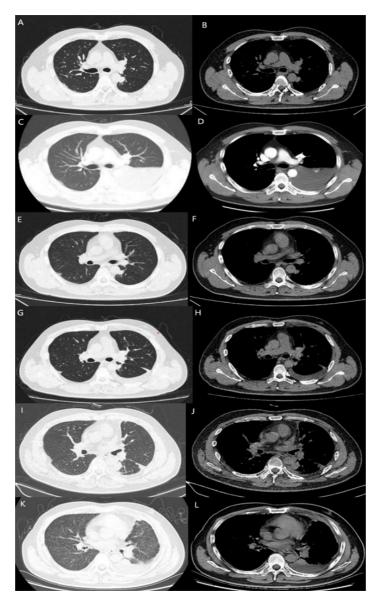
Chestcomputed tomography A and B Proximal mediastin altubercle of in feriorlobe of lef tlung C and D Massive pleural effusion on the left E and F After 3 cycles of chemotherapy and immunotherapy G and H After 7 cycles of che mother apyandimmun other apy I and J After 10 cycles of Pemetrexedin combination with camrelizumab K and L After 8 month so for alanlotinib.
